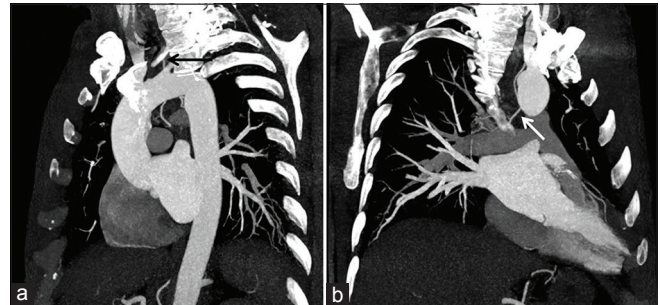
Oblique sagittal (a) and coronal (b) reconstructed thick maximum intensity projection (MIP) images from computed tomography angiography (CTA), showing the origin of the right bronchial artery from the left common carotid artery (CCA) (arrow in A) and the tortuous course toward the right hilum (arrow in B)
